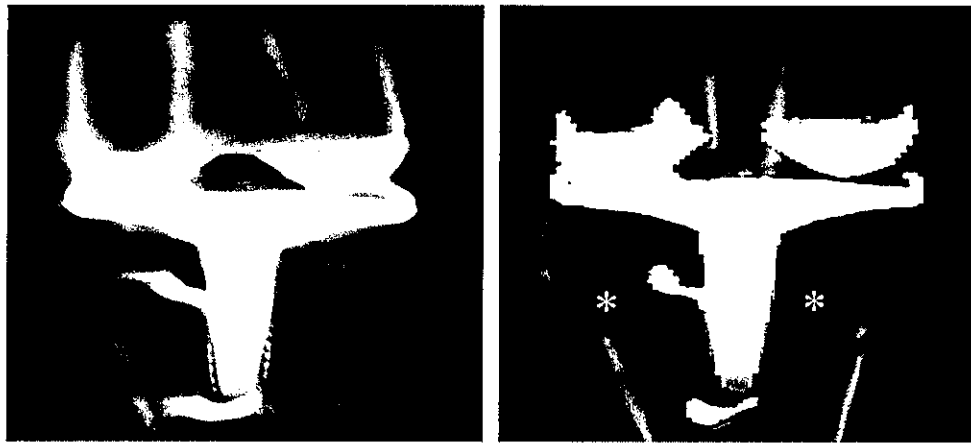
Beam-hardening correction in vertebral fusion. Axial VMS CT images of the lumbar spine obtained at 70 keV (a) and 140 keV (b) show fixation hardware at L4-L5.
